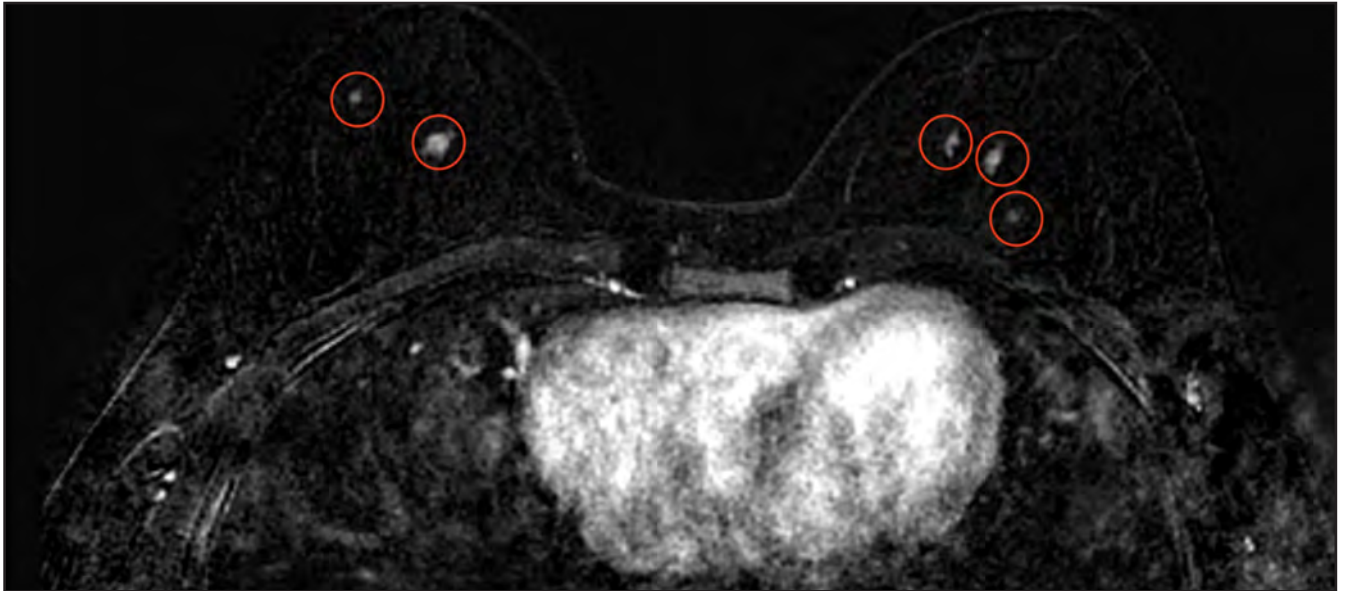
Bilateral T1-weighted, contrast-enhanced subtraction breast MRI in the axial plane; first postcontrast phase demonstrates multiple bilateral oval enhancing masses (circles). No discrete enhancement could be seen at the site of right 1 o'clock biopsy (not shown). Ultimately, the decision was for surveillance due to the number and similarity of lesions. A follow-up MRI in six months demonstrated stability. Discharge did not recur after biopsy.
